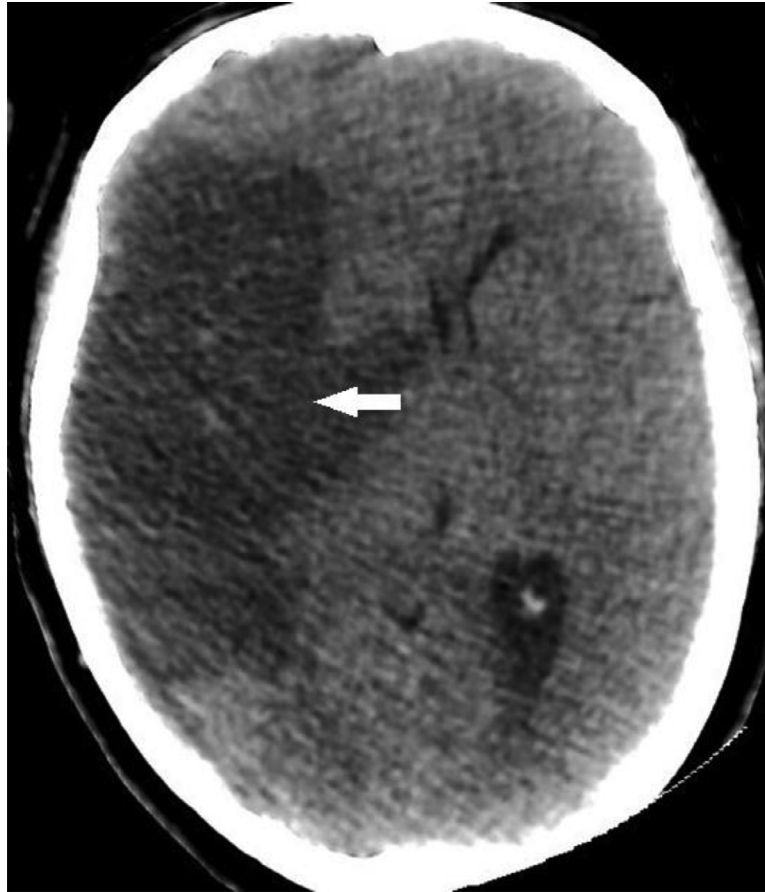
CT of the head, axial plane showing right hemispheric ischemia with cerebral edema (White arrow) responsible for a mass effect on the midline structures.
